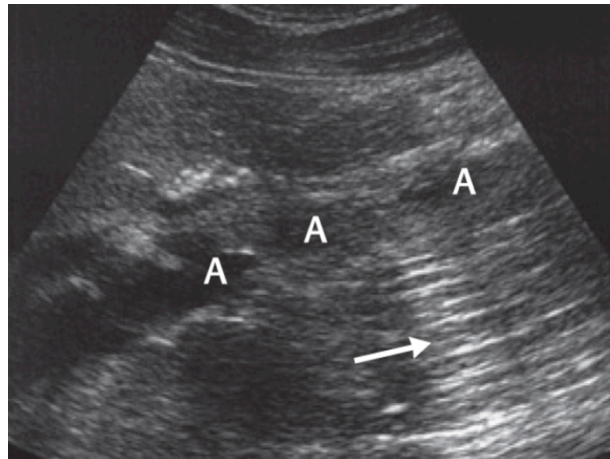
Reverberations. Multiple line-shaped reflections (arrow) perpendicular to the ultrasound beam. "A" indicates the position of the wall of the aorta.
